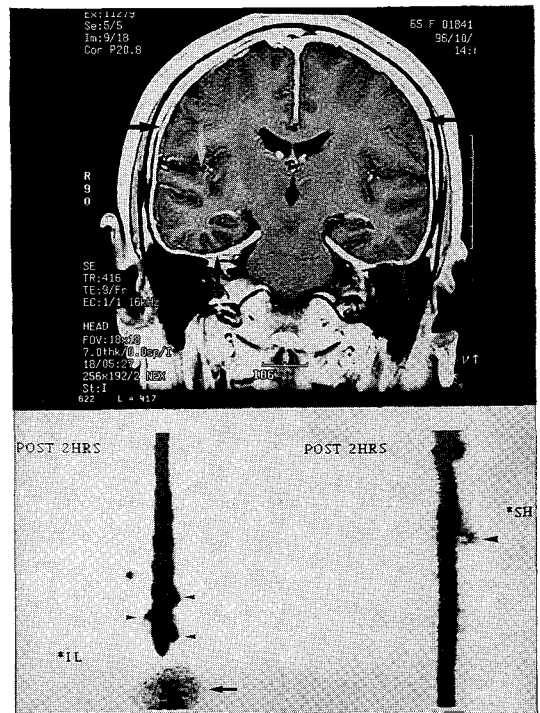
Brain MRI of 66-year-old woman with spontaneous intracranial hypotension depicts mild dural thickening, mild suprasagittal vein engorgement and diffuse pachymeningeal enhancement (arrows)(1A). ^{99m}Tc-DTPA RN cisternography shows multiple areas of CSF leakage at cervicothoracic junction and lumbar region (arrows) with early visualization of the bladder(1B). (IL; ilium)
